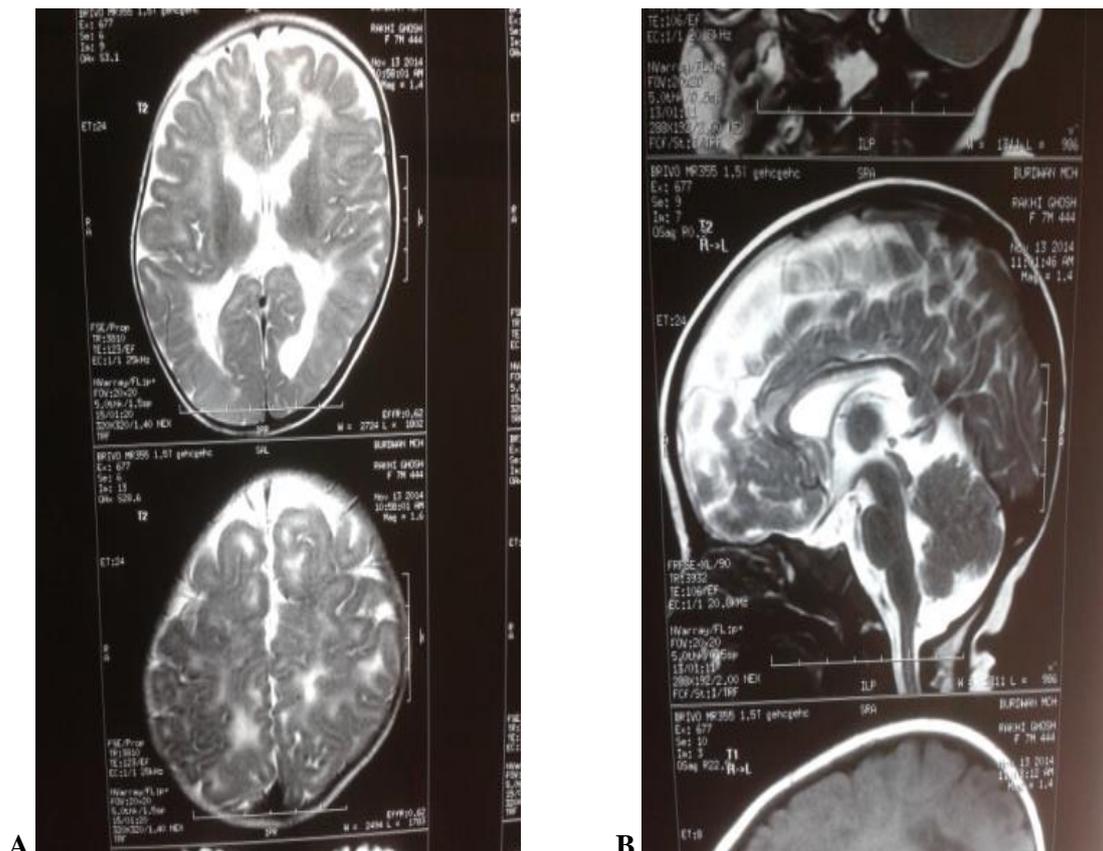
T2W Brain MRI images. A: bilateral hyperintense posterior periventricular white matter and centrum semiovale with bilateral temporal cystic changes. B: extensive demyelination.
